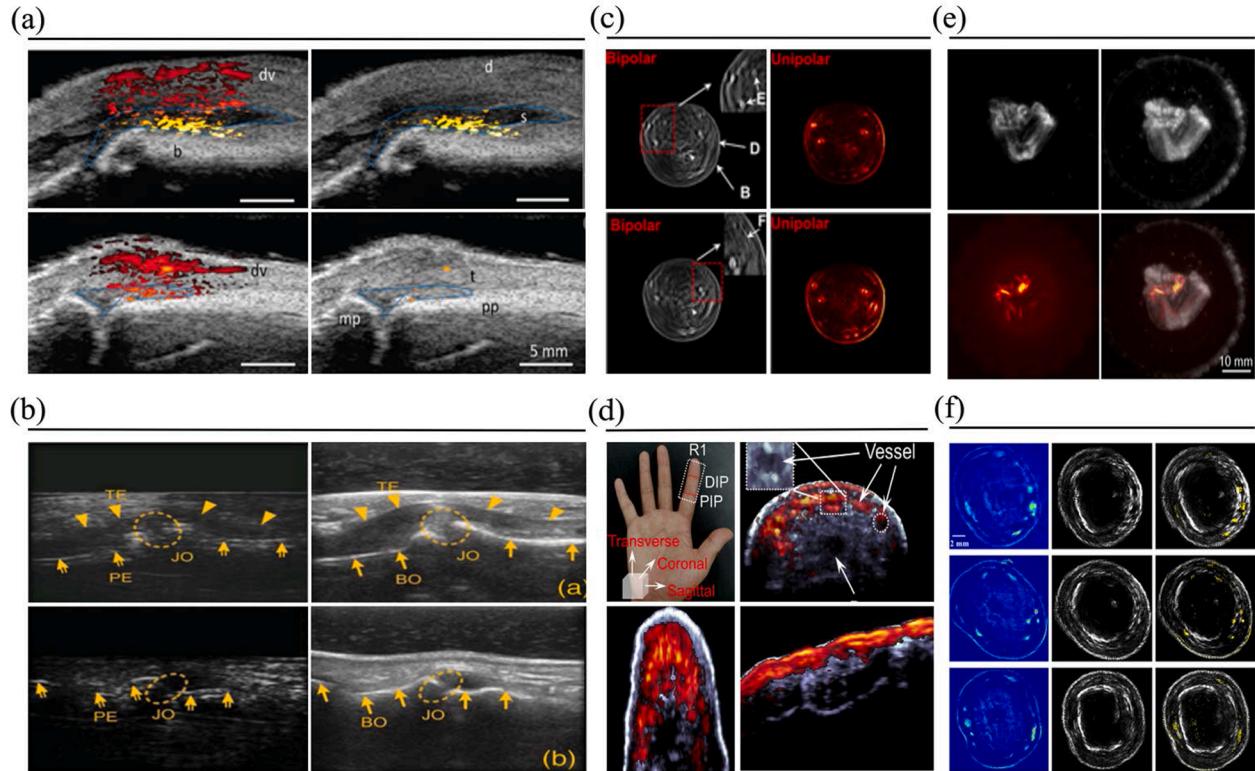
PACT-US Human limb joint imaging applications. (a) PACT-US images show a difference in color between inflamed and non-inflamed corresponding to an increase in amplitude levels [90]. (b) A comparison of PACT and US images of the proximal interphalangeal (PIP) joint was shown in normal volunteers. (c) In vivo PACT-US imaging of Human finger joint [91]. (d) Photography of the finger and representative co-registered harmonic US and PA images in the coronal, sagittal, and transverse planes [78]. (e) Photoacoustic ultrasound image of finger joint cross-section. (f) In vivo PA (upper row) and US (middle row) reconstructed images of typical joint slices [92].
